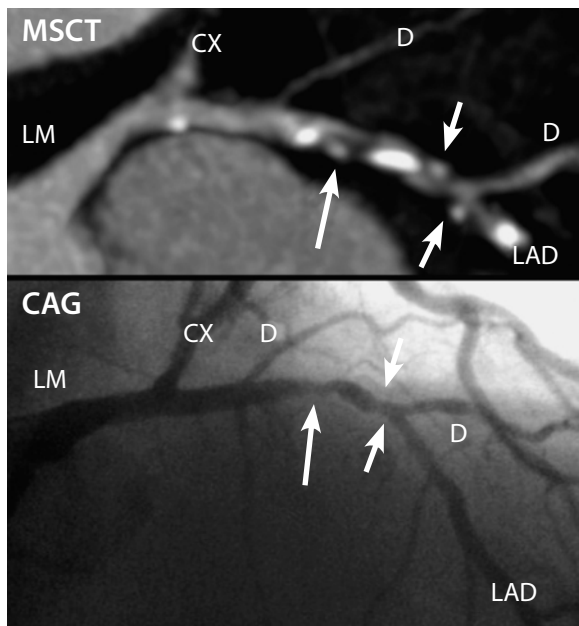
Diffuse disease of the LAD, examined with 16-slice CT. The segment between the left circumflex (CX) and first diagonal branch (D) contains bright calcified and dark non-calcified plaque material. The conventional angiogram shows that, despite the corresponding locations of the plaques (*arrows*), the vessel is at no point narrowed by more than 50%. LM Left main coronary artery
